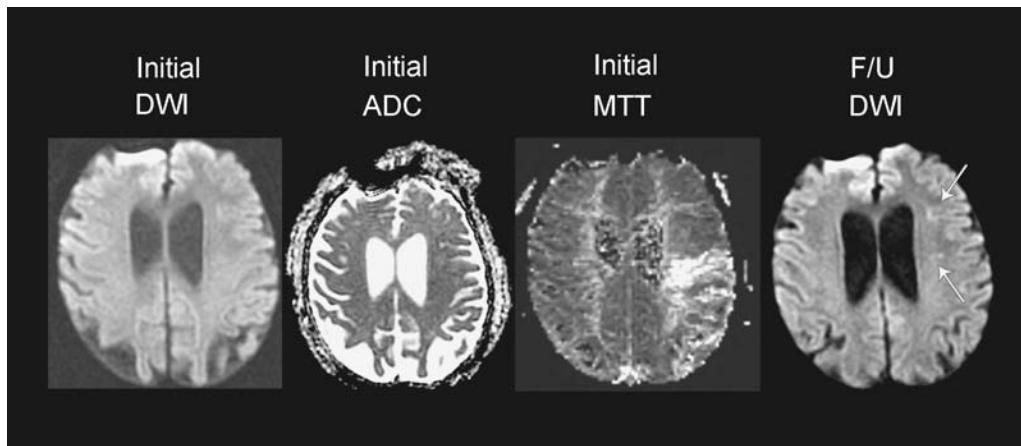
Acute stroke with normal DWI but abnormal perfusion (MTT) images. Seventy-two-year-old male with right-sided weakness imaged at five hours after symptom onset. Initial DWI image demonstrates no acute infarction. The MTT map demonstrates delayed MTT in the left posterior frontal and parietal lobes. The follow-up DWI image demonstrates punctate infarctions in the left corona radiata (arrows). Abbreviations: DWI, diffusion-weighted images; MTT, mean transit time.
